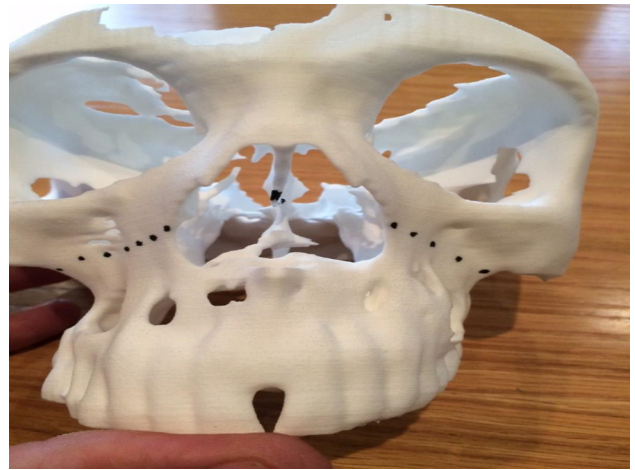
The anatomical planning model which was additive manufactured from CT images, with dotted lines demonstrating the planned excision plane.
